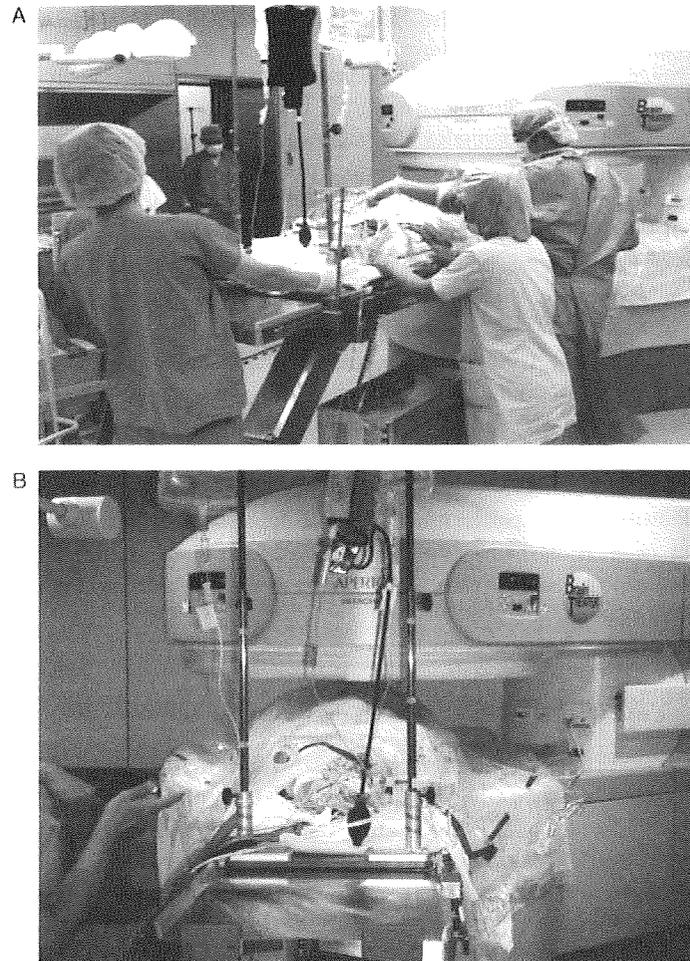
Setup position for intraoperative MRI during neurological surgery in Brain Theater.
